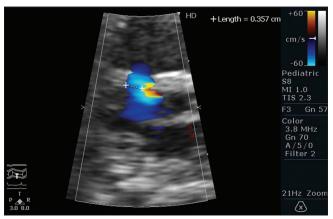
Fetal echocardiogram showing left to right shunt across ventricular septal defect - zoomed view
